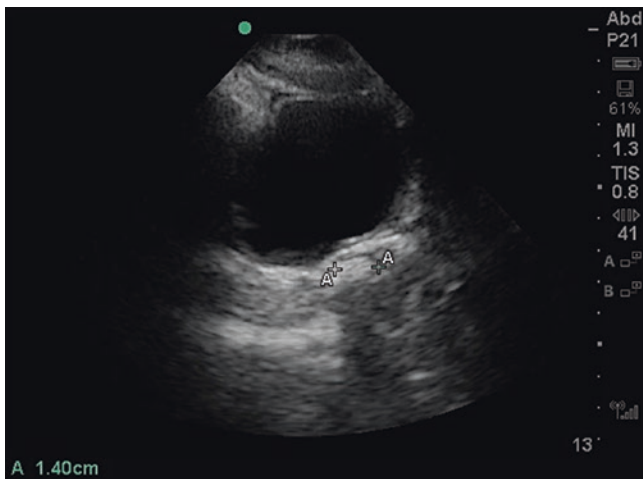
Ultrasound image of a renal stone in the ureterovesicular junction (UVJ). This is the most common site of renal stone obstruction. (Image courtesy of Bret Nelson.)
